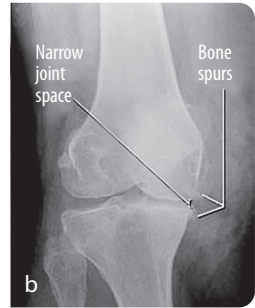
X-ray of (a) a normal joint and (b) an osteoarthritic knee which shows reduced joint space and bony spurs (osteophytes).
